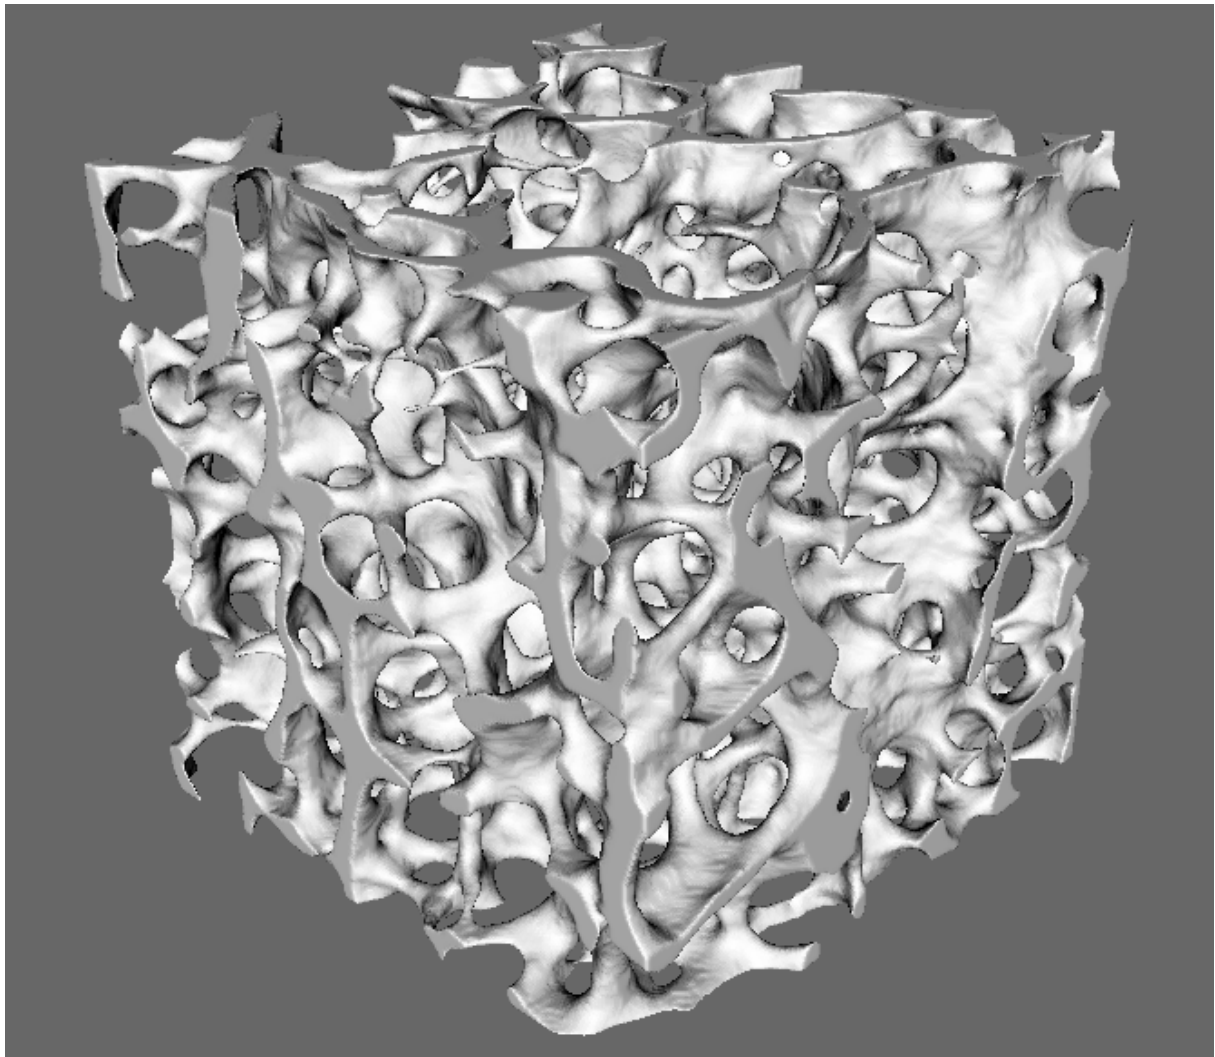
Three dimensional reconstruction of a cube of vertebral trabecular bone imaged using μ CT.
